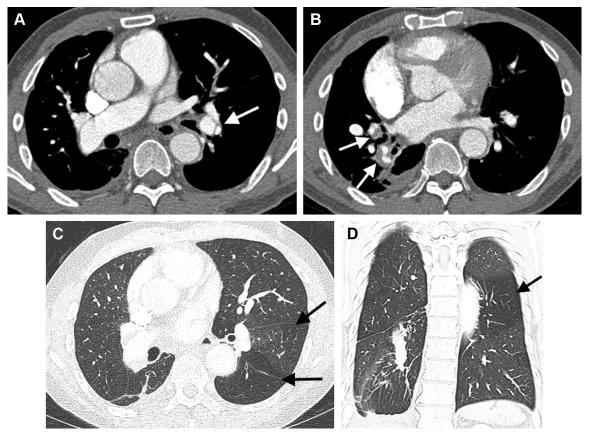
A-D, Axial CT pulmonary angiographic images on mediastinal windows in a 57-y-old man with a history of chronic pulmonary embolism and pulmonary hypertension. A, Proximal left lower lobe pulmonary artery web is shown (arrow). B, Right lower lobe mural-based segmental pulmonary arterial filling defects with associated luminal narrowing (arrows) is shown. C, Axial and coronal (D) CT images on lung windows in the same patient showing mosaic attenuation in the superior segment of the left lower lobe (arrows).
